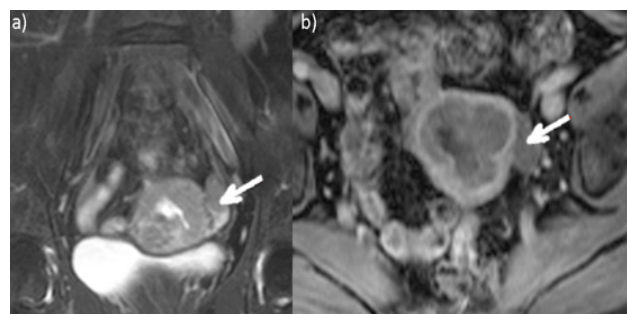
Pelvic MRI: a) T2W and b) T1W C+ images show adnexal metastasis (arrows) (stage IIIa).
